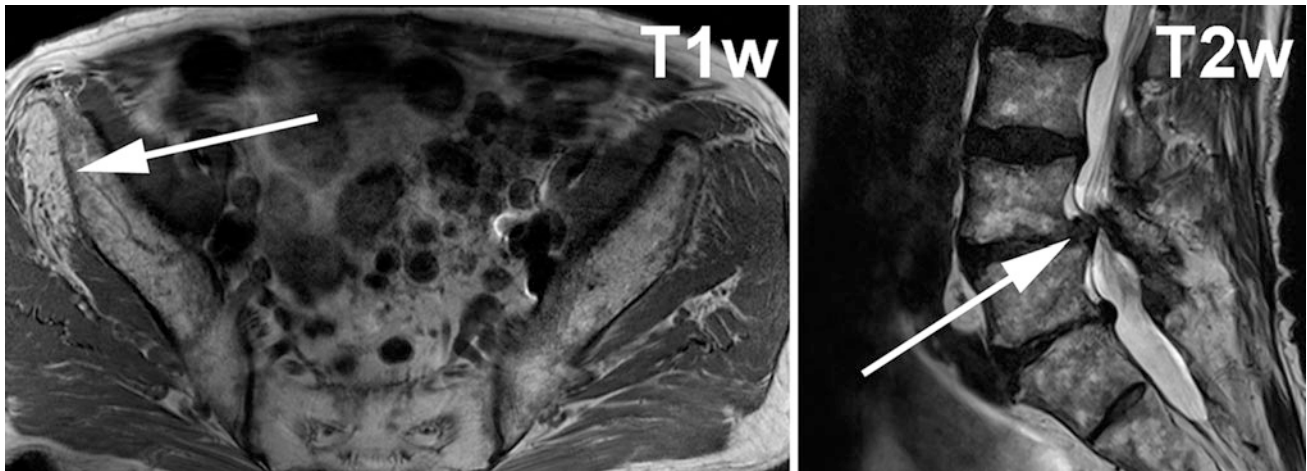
Left image* shows T1-weighted axial slice through gluteal region. On the *right side* of the patient (*solid arrow on left*) the gluteus minimus muscle shows strong T1w hyperintense signal alteration indicating fatty atrophy in the chronic stage of denervation. The
